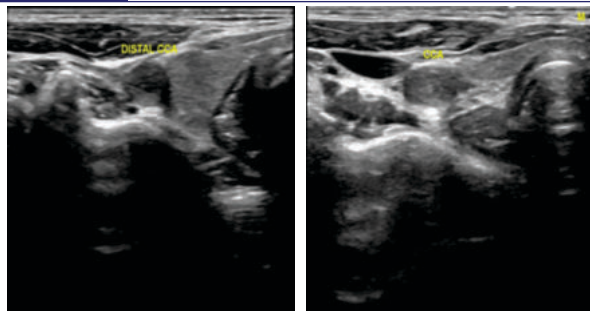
CASE 2: Ultrasound of the distal part of right common carotid artery shows progressive increase in wall thickness causing stenotic narrowing of the vessel.
